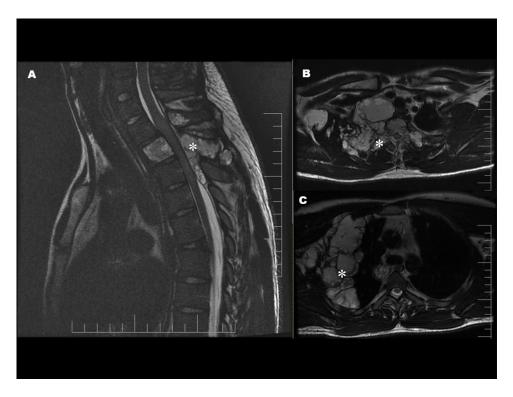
(A) MRI T2-weighted image, sagittal view, spinal hydatidosis affecting the vertebral body of T2 (white arrow) and the posterior elements of T1, T2 (white asterisk), and T3. (B) MRI on T2- weighted image, axial view, showing lesion of the anterior (white arrow) and posterior elements (white asterisk) of T2. (C) MRI on T2- weighted image, axial view, showing lesion involving of the second costal arch on the right with the involvement of the soft parts around.
